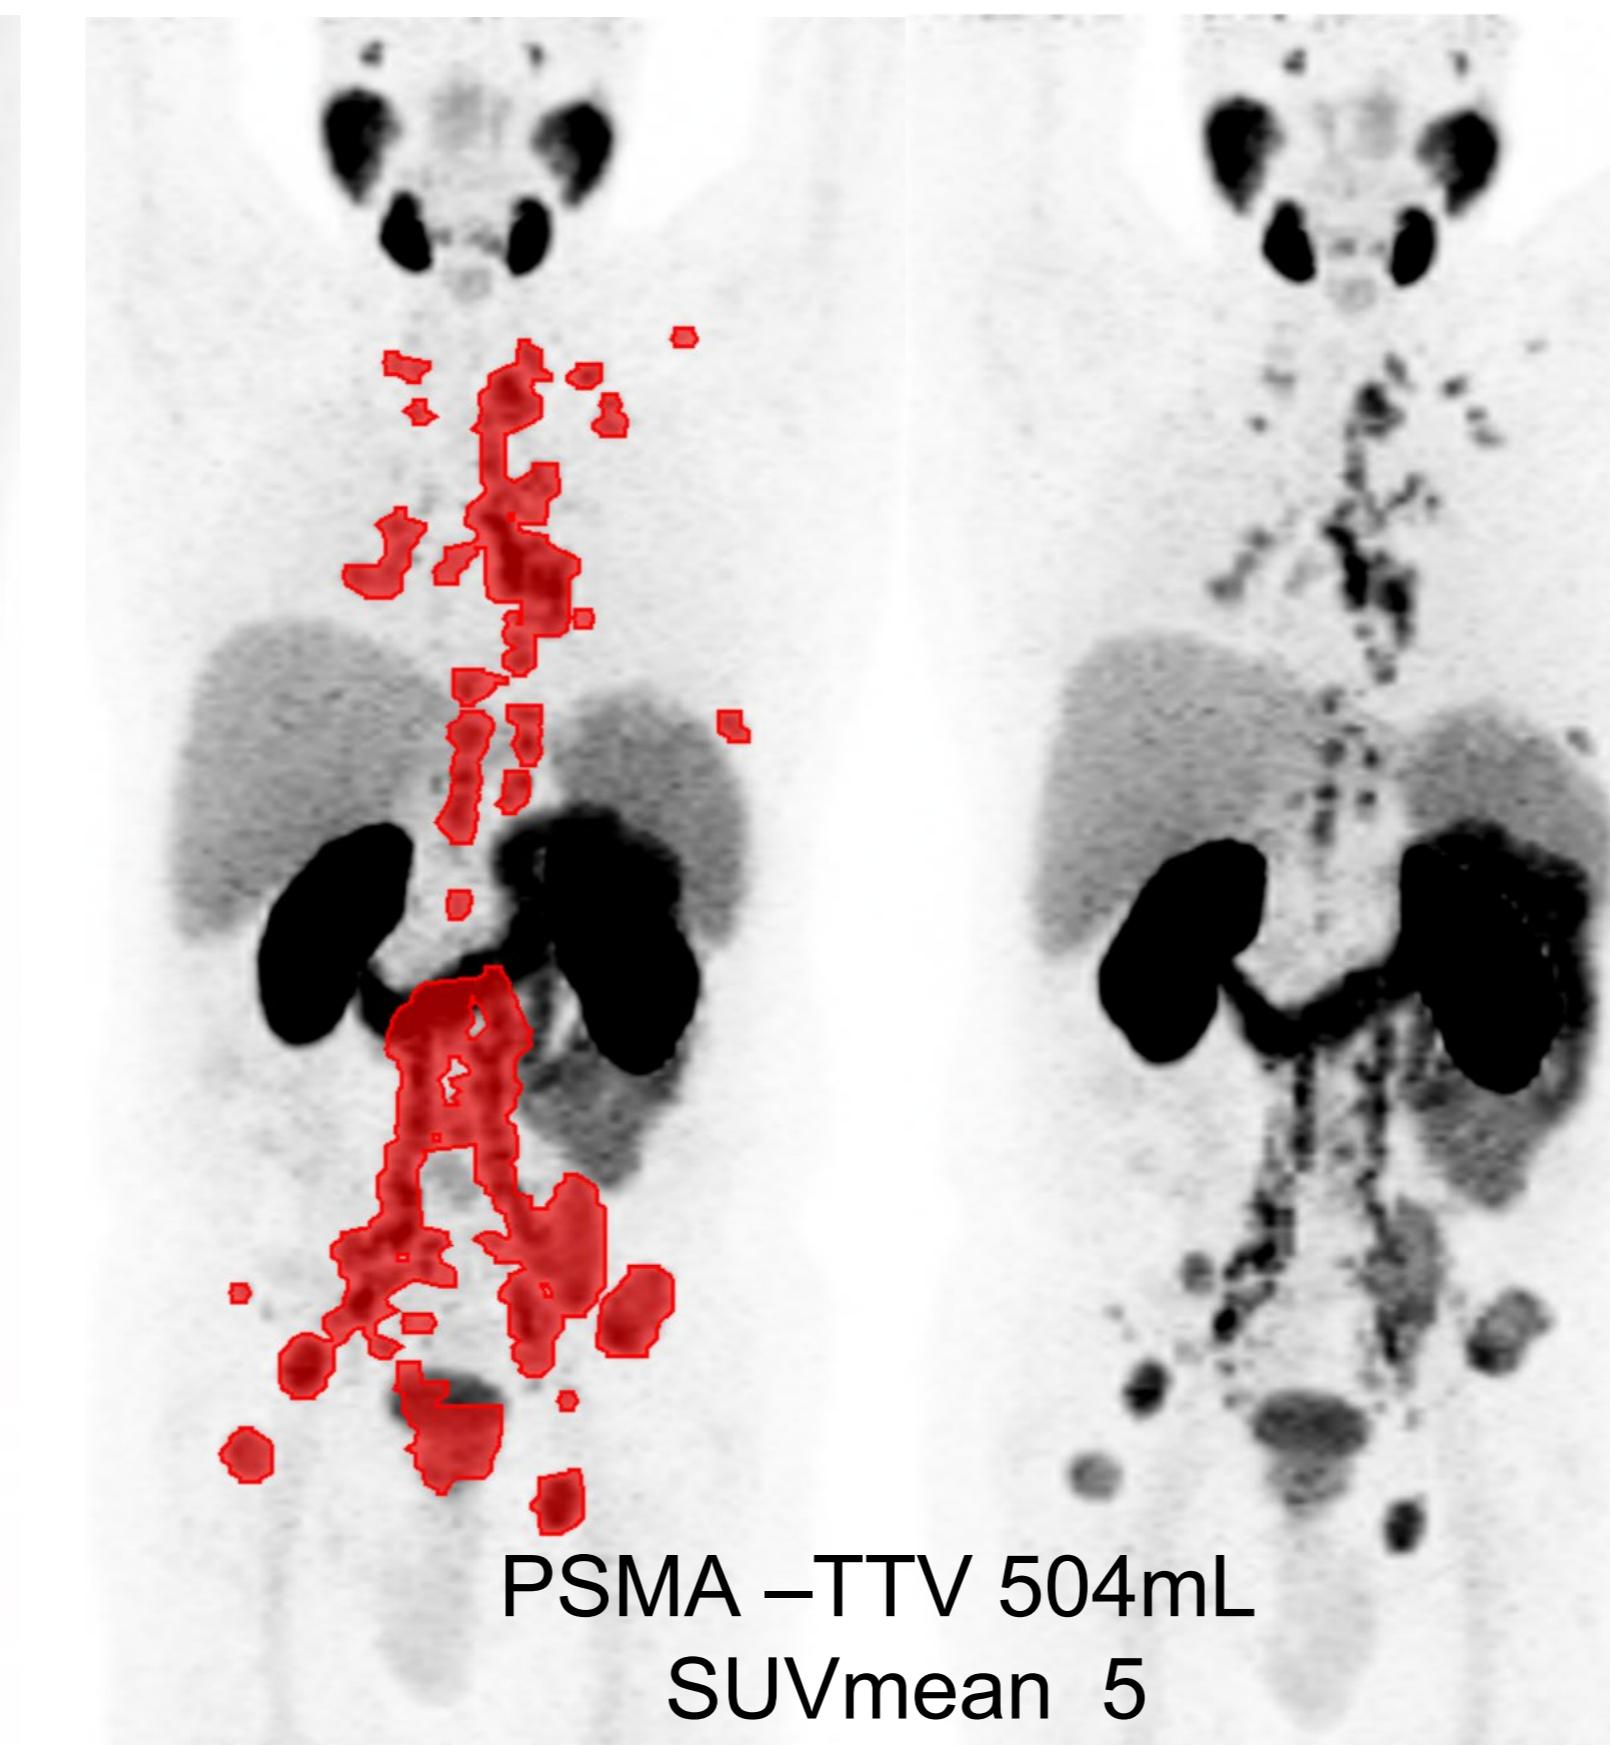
PSMA-PET with high volume nodal and bone metastases.
